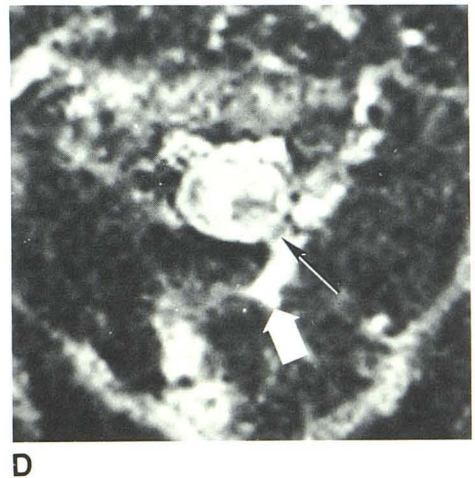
A, Sagittal MR image shows posterior displacement of cord with a focal bulge (arrow) and an area of decreased signal immediately cephalad. Residual surgical wire causes artifact near posterior spine (arrowheads).
